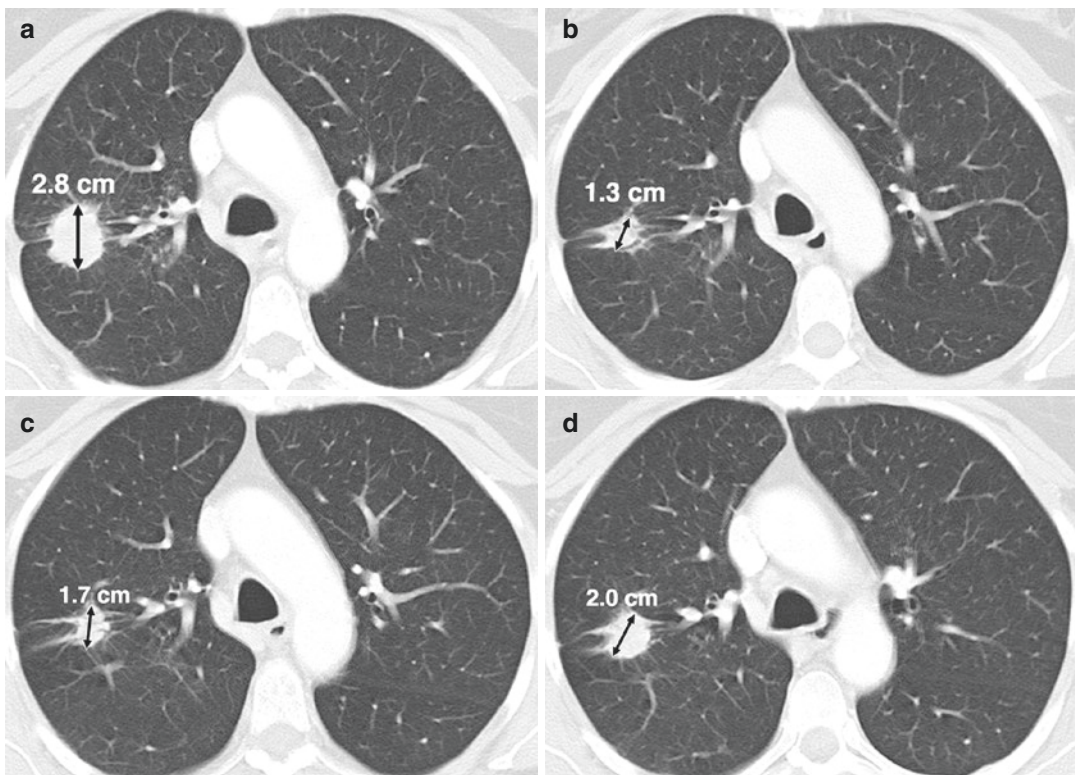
Disease progression in 55-year-old woman with NSCLC treated with EGFR inhibitor erlotinib. (a) CT scan of chest shows spiculated right lung lesion, which is the only target lesion, has longest diameter of 2.8 cm (arrow). (b) After one cycle of therapy, lesion measures 1.3 cm (arrow), showing 54% decrease in size compared with baseline. This change is consistent with partial response. (c) After initial response, small residual tumor slowly increased in size and measured 1.7 cm (arrow) on a further follow-up study. Given 30% increase compared
